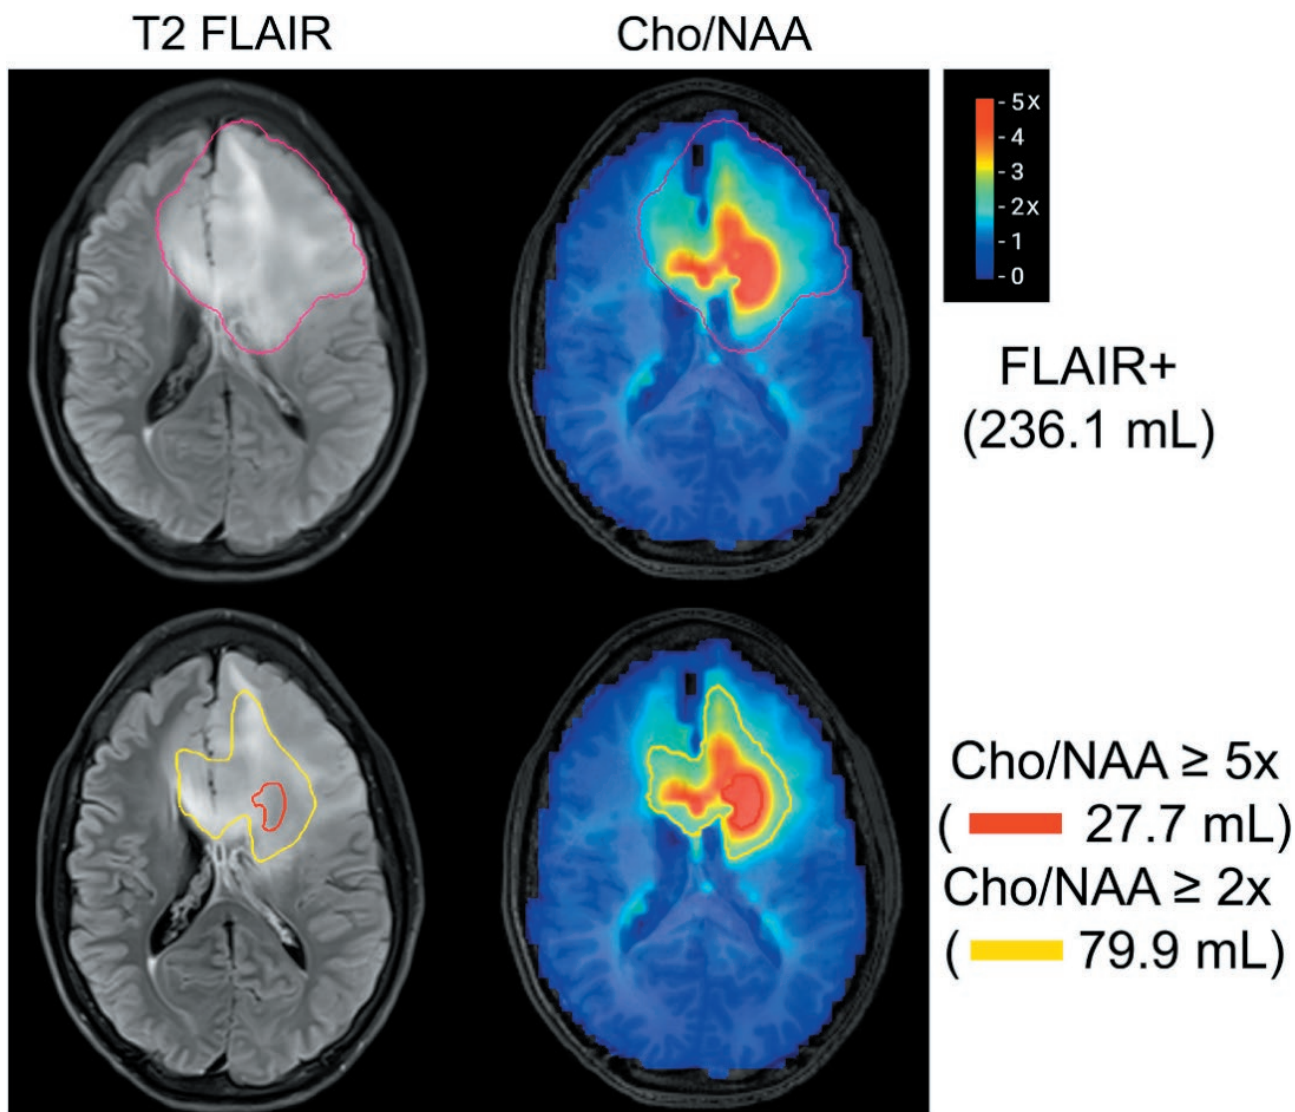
Upper Left Image: FLAIR image of a Grade II Astrocytoma with segmented volume of hyperintensity (pink outline) compared to Upper Right Image: T1 image overlaid with an MRSI colormap of tCho/NAA ratio. Lower Right Image: Outlined volumes show boundary for tCho/NAA of 2x (yellow) and 5x (red). The areas of highest tCho/NAA were targeted for biopsy. The upper and lower images are the same images, only the outlines are different. The tCho/NAA from normal contralateral white matter was set as equal to 1.0. Reprinted by permission from Springer Nature, Reference 168, Copyright 2021.
